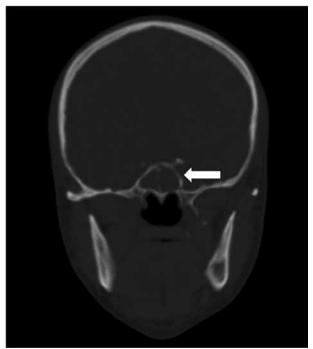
Coronal CT demonstrates the sphenoid sinus opacification and the lysis of the left sphenoid sinus wall (arrow).
